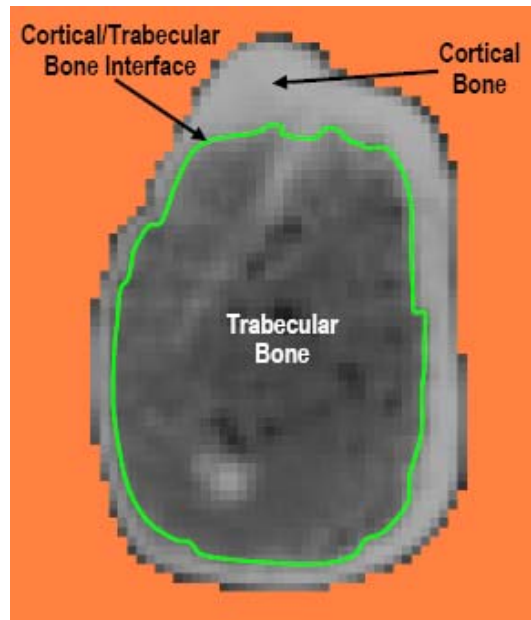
A typical computed tomography (CT) scan of the femur showing the presence of two bone tissues (cortical and trabecular bone tissues) and density variation within each bone-tissue.
